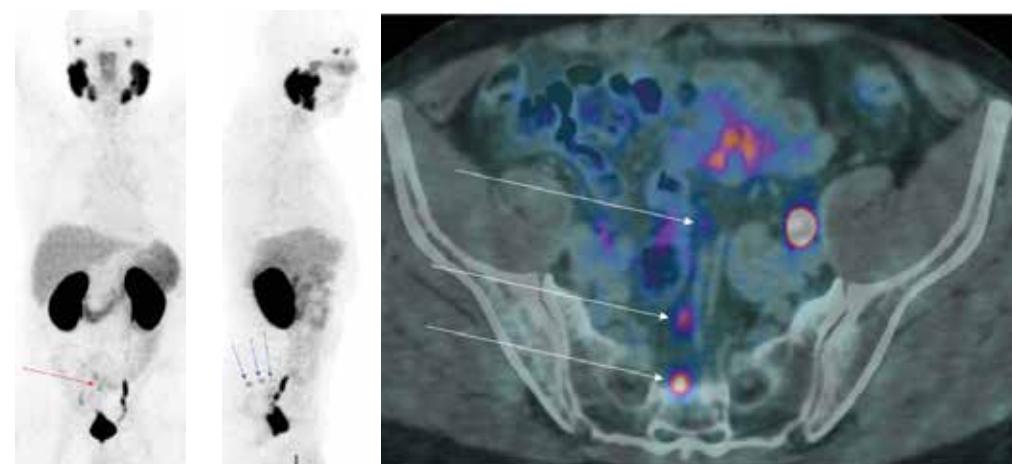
67 yo patient, PSA persistence (0.18) after RARP (pGS: 4+4; iPSA 8.5; pT3aN1R1 with 19 lns removed) PSMA PET: small focal areas of pathologic uptake (left image, coronal view, red arrow), attributable to three small lymph nodes (centre image, sagittal view, blue arrows). The focal nodal uptake is better seen in PET/CT transaxial image (right, white arrows)
